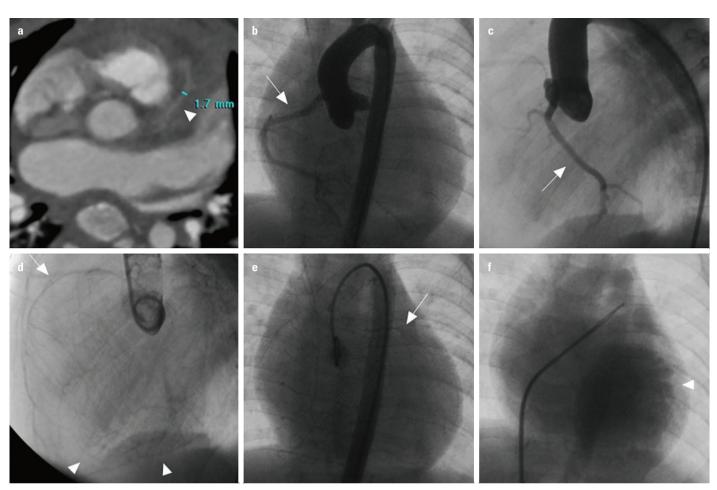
(a) Multi-slice computed tomography shows the LCA (arrowhead) is unconnected with either the aorta or pulmonary artery. (b, c) Aortic root angiography shows a mildly dilated RCA (arrow) from the right sinus without normal LCA origin. (d, e) Later images show a hypoplastic LCA (arrow) filled retrograde via collateral networks (arrowhead) from the RCA to the LM. (f) Contrast recirculation into the left ventricle after pulmonary artery angiography shows spongy ventricular myocardium (arrowhead)
